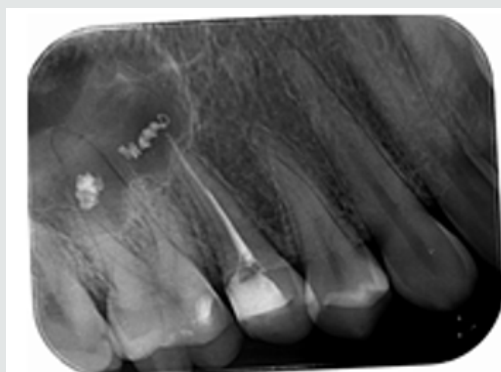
Postoperative periapical radiograph immediately after the obturation.
